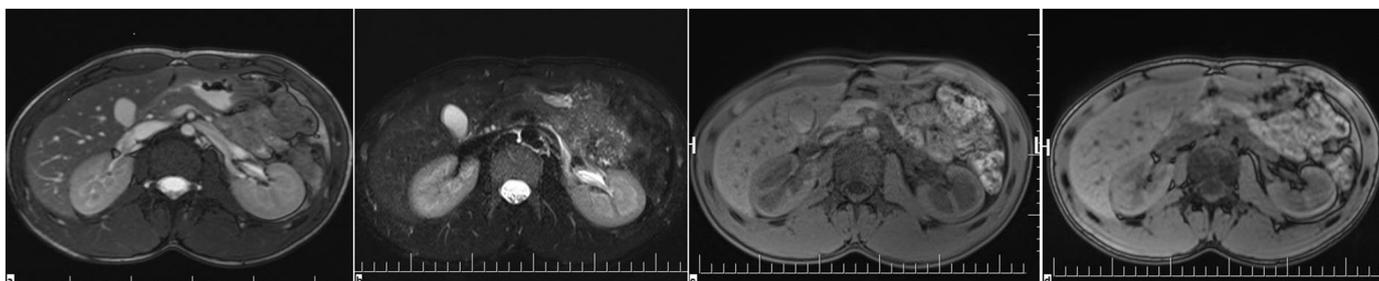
Axial MRI images (a; T2-TRUFI, b; T2-HASTE, c; T1-VIBE, d; Out-of-phase T1 sequence): compressed left renal vein between aorta and superior mesenteric artery.
